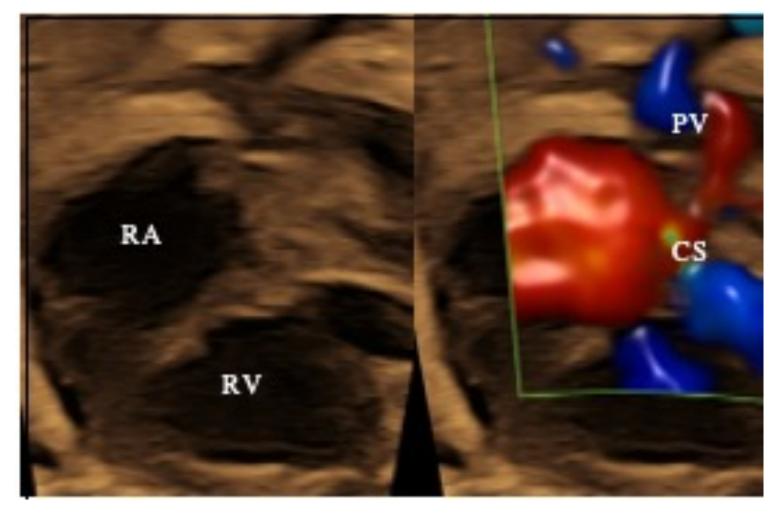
Fetal echo apical 4 chamber with color compare showing large RV, small LV, and at least 1 pulmonary vein entering the coronary sinus
